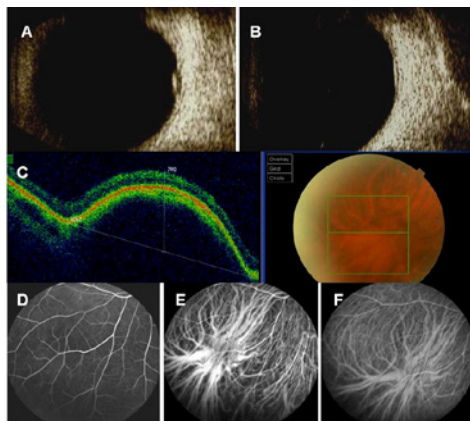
Ultrasonography, OCT, and Angiography in case 1. A By a longitudinal B-scan on the 7 o'clock meridian, a dome shaped lesion of 1.4mm × 3mm on the posterior equator eye wall with high reflective smooth surface and low internal reflectivity was found. B The lesion diminished seconds after probe pressure. C Spectral domain OCT showed an elevated area in the inferiotemporal fundus. The neuralretinal layer and the retinal pigmental epithelial layer bulged into the vitreous with a 4067µm wide 790µm height dome shape, with normal reflectivity and good continuity. The reflectivity under the RPE layer was lowered. D During venous phase, FFA showed no abnormal lesions. E Corresponding ICGA showed enlarged vortex vein ampulla filled obviously with density vascular bundle. F The filling gradually diminished until the late phase. No fluorescein leakage was found.
